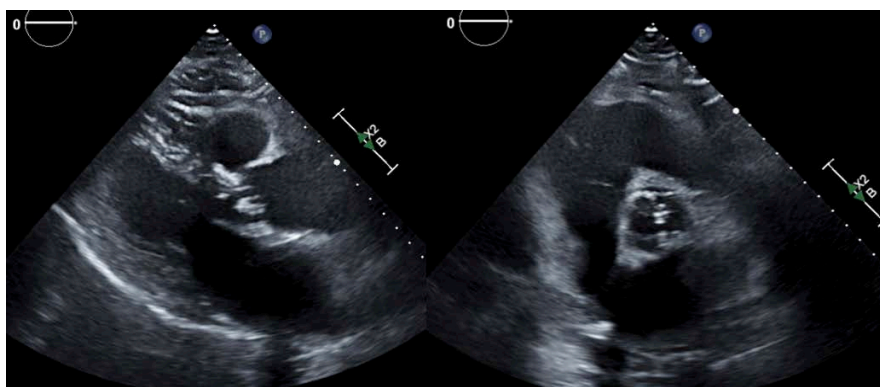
Transthoracic echocardiogram demonstrating vegetation of the aortic valve
